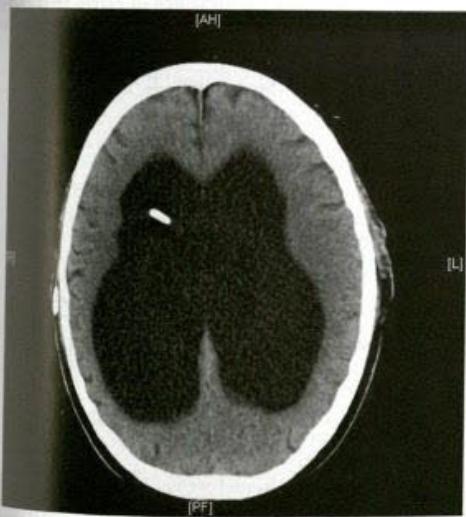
Axial CT of a postoperative patient with normal-pressure hydrocephalus demonstrating persistent ventriculomegaly despite a working shunt (note the absence of periventricular lucency). This patient made only a small improvement.
